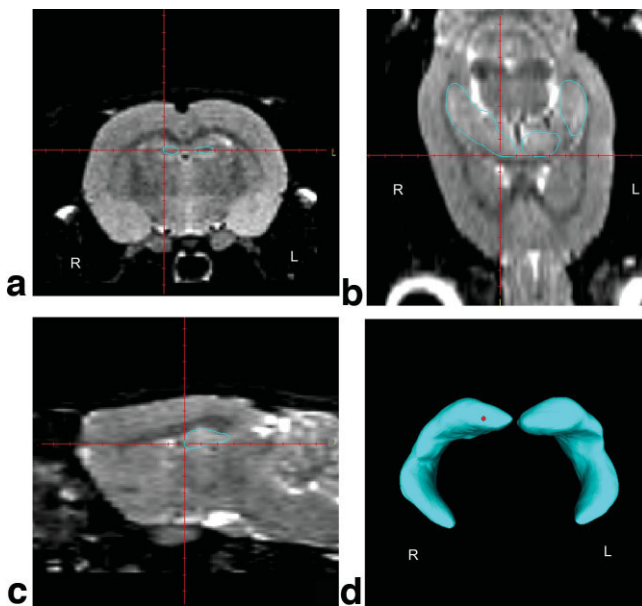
a–d: A three-dimensional representation of the surface of the hippocampi (D), with associated two-dimensional MR images in the coronal (A), horizontal (B), and sagittal (C) planes. A marker is placed over the rostral aspect of the septal pole of the right hippocampus, which corresponds to the intersection of the crosshairs on two-dimensional images. Hippocampal surface outlines are presented on A–C. In D, the hippocampi are viewed from a rostral position, with the temporal pole projecting to the lower part of the image.
